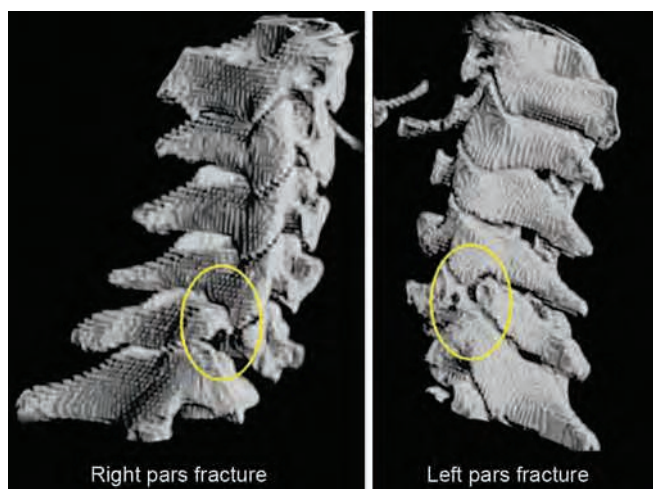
Three-dimensional reconstructed computed tomography scans of the cervical spine. Yellow circles indicate the bilateral location of cervical spondylolysis at C6.⁸
